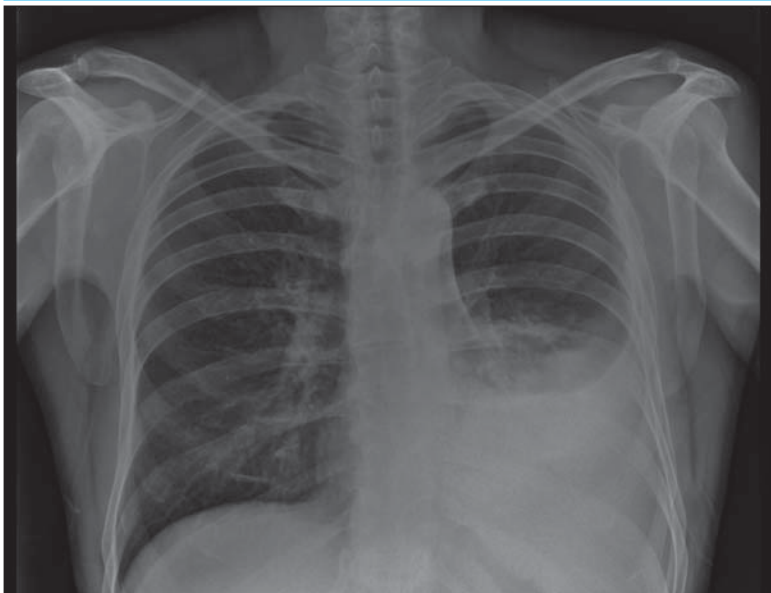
Chest X-ray from case report.
